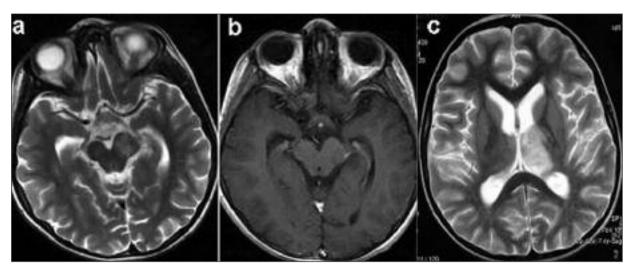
Control MRI performed three months after the first presentation. Axial T2 weighted (a), postcontrast T1 weighted (b) images obtained at the same level and axial T2 weighted image from the basal ganglia (c) shows a significant resolution of the increased intensities at the left cerebral peduncle, thalamus and optic chiasm. No enhancement was observed at the left cerebral peduncle at this stage.
